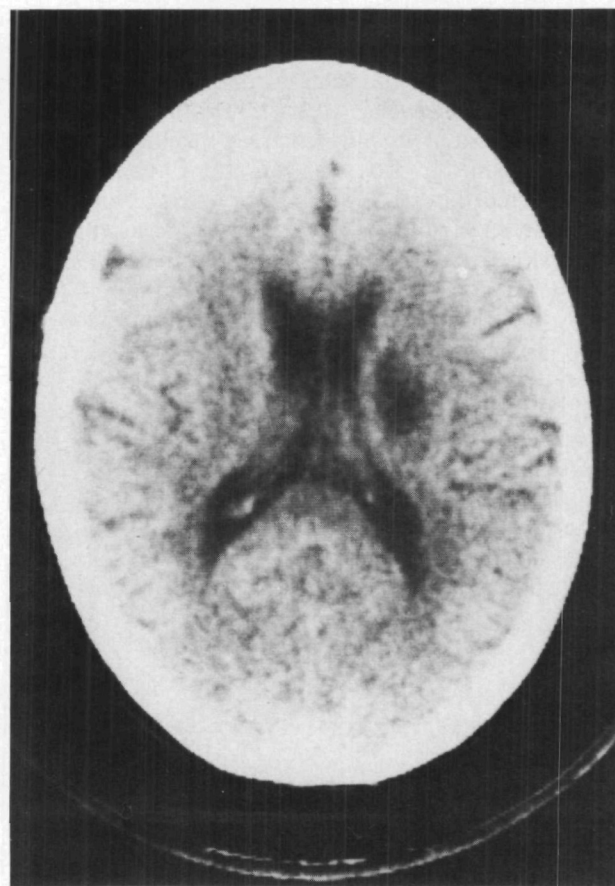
Case 1. CT scan on day 8 demonstrating lacune in the corona radiata.
